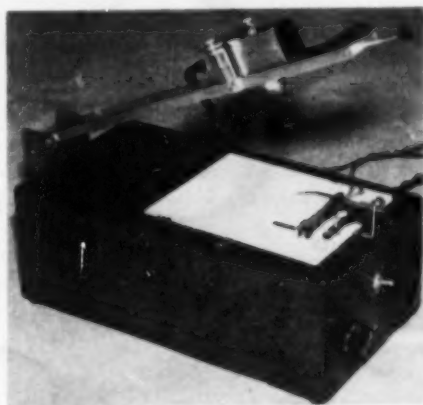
(von Sallmann and Dillon). Densitometer used on radiographs.
